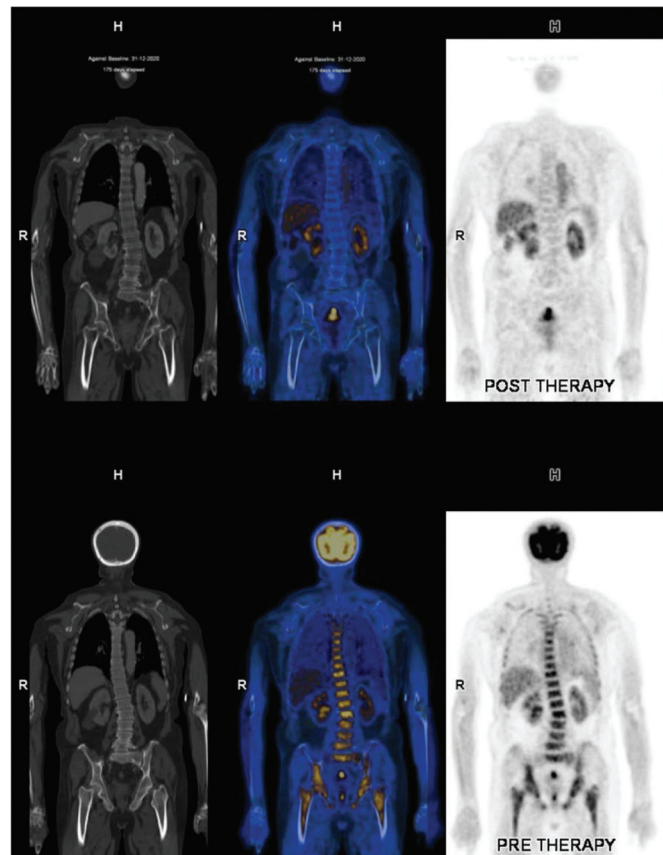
CT, PET/CT fusion, and PET images respectively (*first row*: posttherapy images; *second row*: pretherapy images) in the coronal section, showing diffuse F-18 FDG uptake with heterogeneity and no CT-detected lesions in pretherapy images and complete resolution of the uptake in posttherapy images. CT, computed tomography; PET, positron emission tomography.
